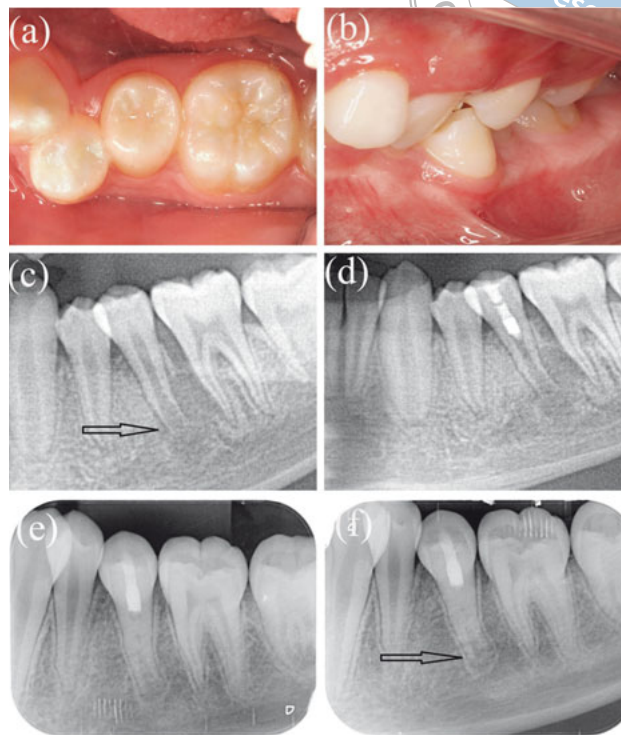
Case 2 intraoral photographs and periapical radiographs. a) Occlusal photograph of tooth 35 at the 8-month follow-up; b) intraoral photograph at the 8-month follow-up c) pre-treatment periapical radiograph of the mandibular left second premolar (tooth 35) showing periapical radiolucency and root immaturity (arrow); d) periapical radiograph taken immediately after placement of iRoot BP in the root canal at the first treatment visit; e) periapical radiograph taken at the 6-month follow-up; the periapical radiolucency disappeared completely; f) periapical radiograph taken at the 8-month follow-up; the thickness of the root wall was increased and the apical foramen was narrowed (arrow).
